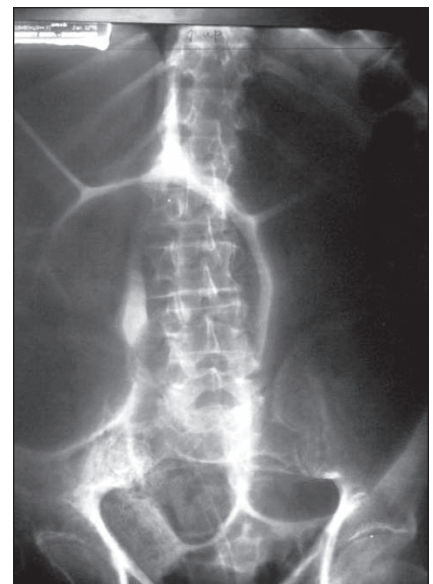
Plain abdominal radiograph of sigmoid volvulus.
